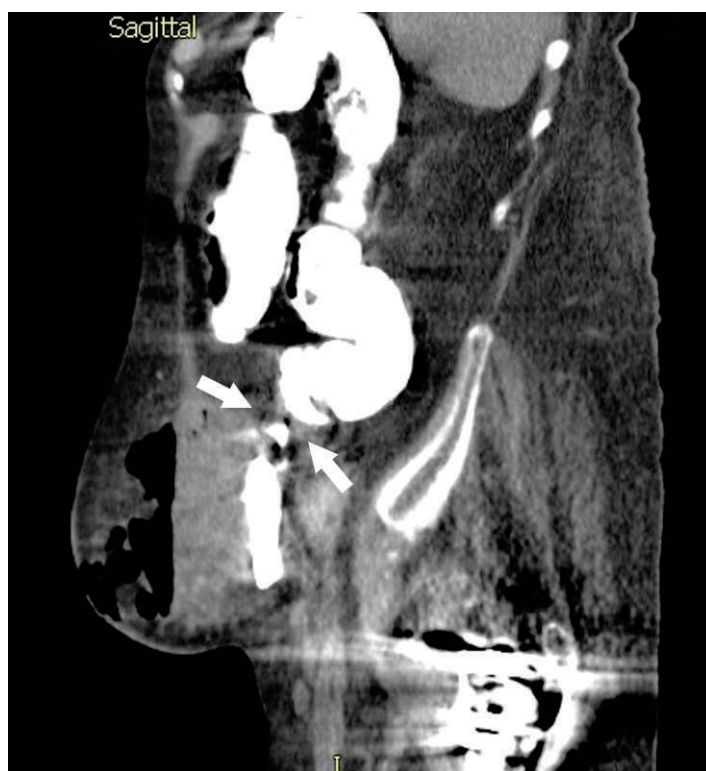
Sagittal reconstruction of abdominal computed tomography showing connection of abscess with the sigmoid colon (white arrows).
